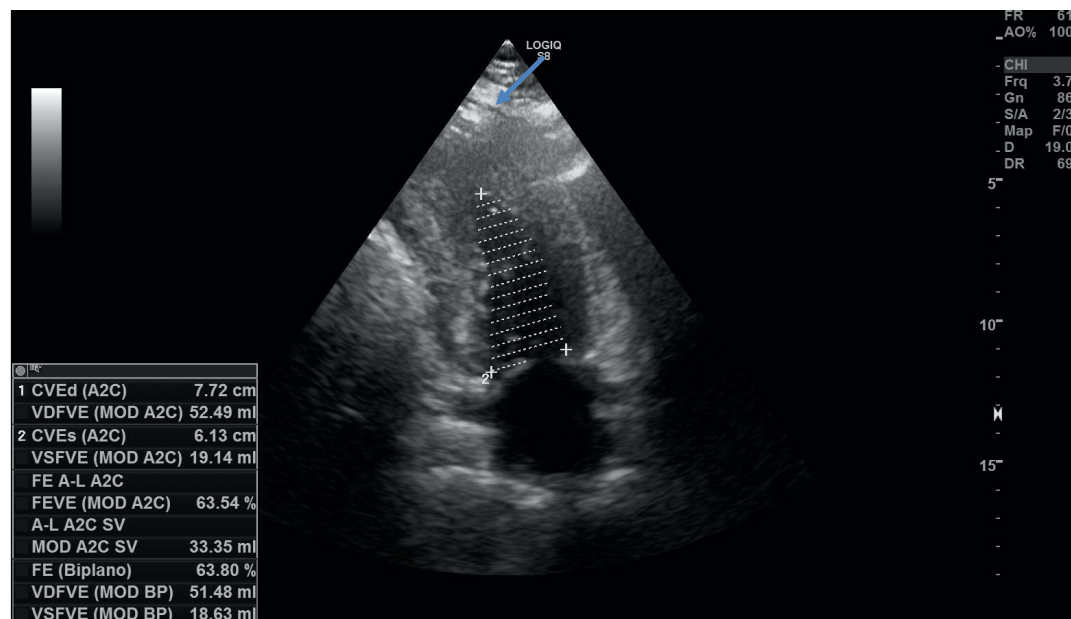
Longitudinal two-chamber echocardiogram demonstrating mid-apical left ventricular hypertrophy (arrow).
